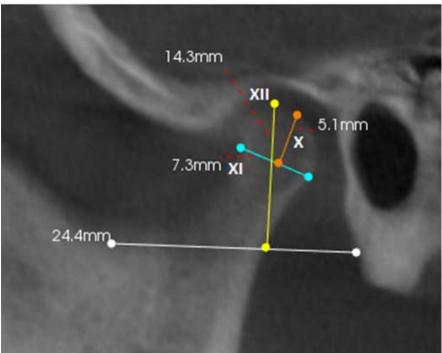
(c):- CBCT Variables and their measurements
